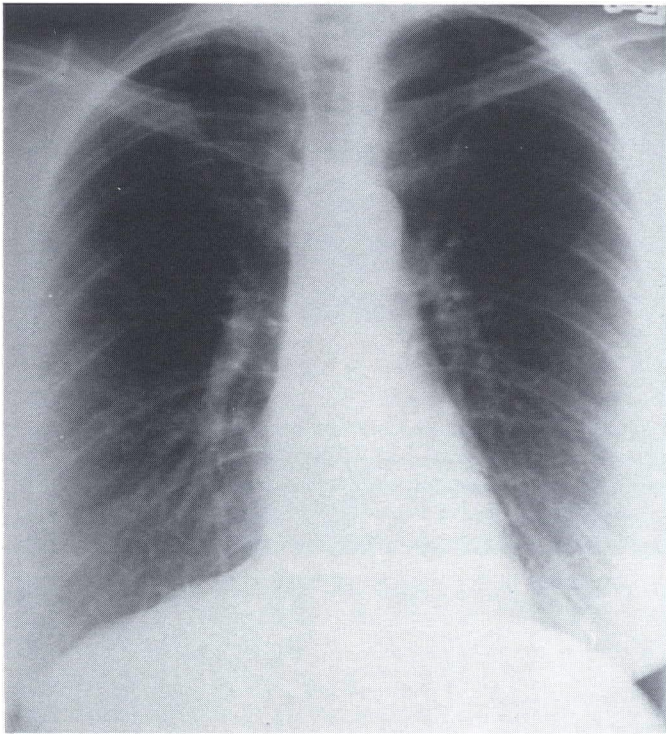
Baseline chest x-ray from two years prior to acute illness. There was no change in the x-ray obtained on first presentation.
